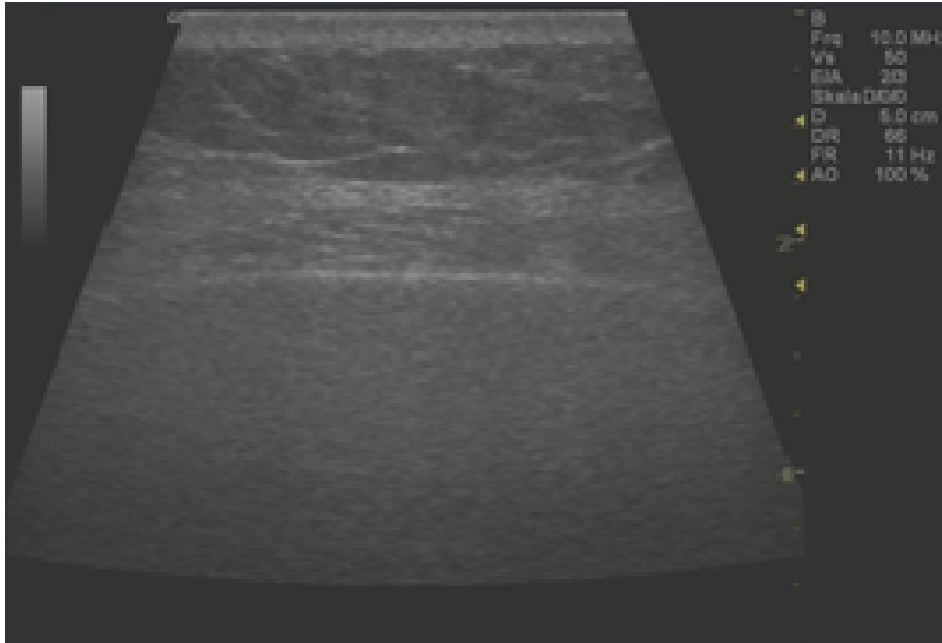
Ultrasound-picture of the liver surface
